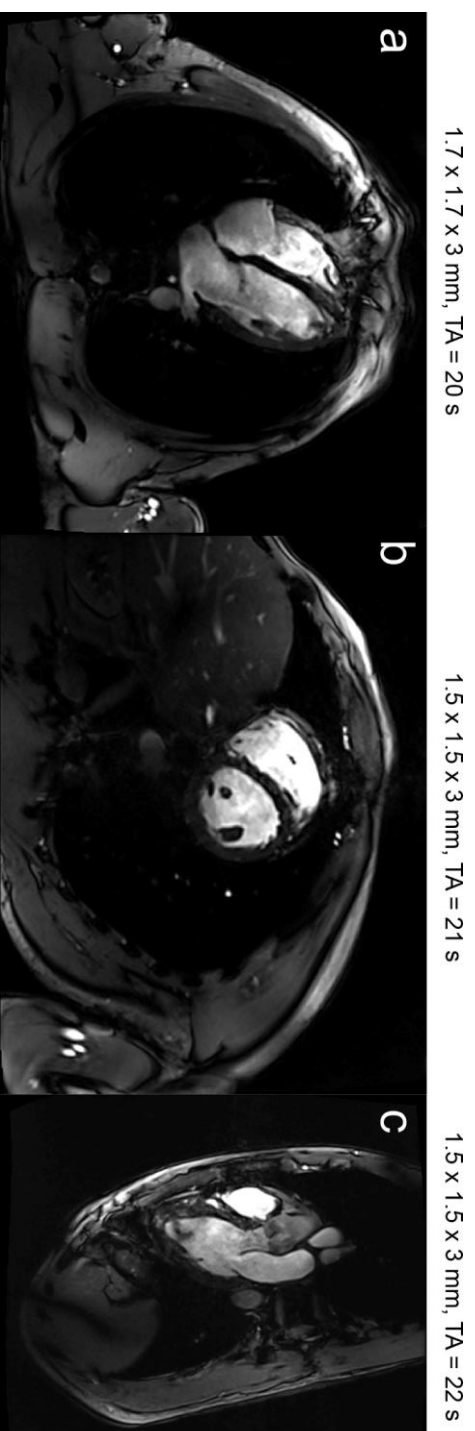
Results for cardiac MRI (a-c) using the 8Tx/32Rx array. For cardiac imaging the 4-chamber (a), short-axis (b) and LVOT (c) views are shown for Volunteer 5 using a FLASH 2D sequence (TR/TE of 41/5 ms, 992 Hz/pixel bandwidth, GRAPPA acceleration factor of $R = 2$) during a single breath hold and utilizing a universal phase-only RF shim. Homogeneous coverage of the heart and excellent blood/myocardium contrast are achieved.
